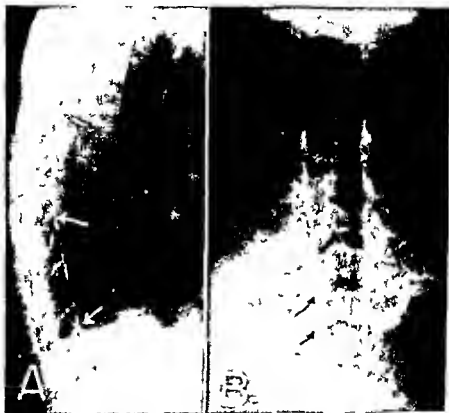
Case No 22, Steatorrhea, Milkman's Syndrome. X-Ray Films to Show Impregnation of Dura with Thoratrust.
